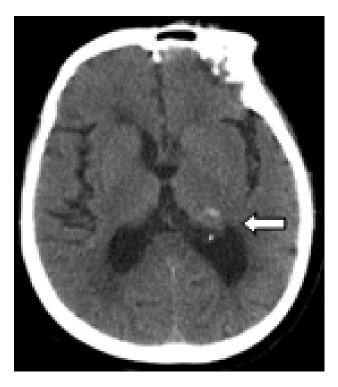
CT image showing a small intracerebral hematoma in the left ventrolateral thalamus.
